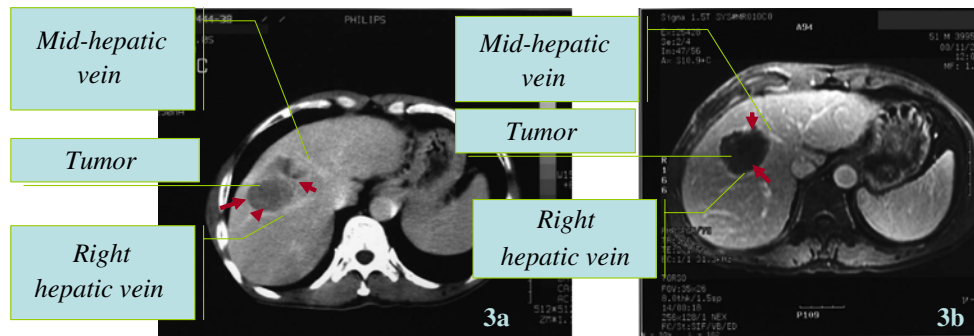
Transverse contrast agent-enhanced CT and MRI of a patient (case 1) with HCC. a Before HIFU. CT obtained in the hepatic venous phase shows a large tumor (bold arrows) located between middle and right branches of the hepatic vein in segment 8. b After HIFU. Venous phase MRI obtained 2 weeks after HIFU treatment
